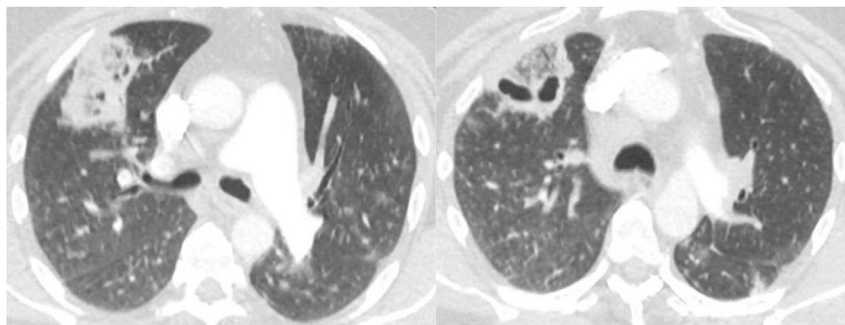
Initial axial Computed Tomography of the chest showing a right upper lobe wedge-shaped peripheral ground glass and cavitory opacities consistent with pulmonary infarcts.
